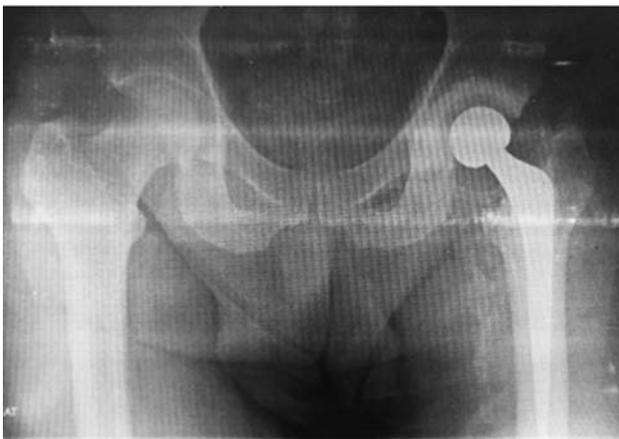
Panoramic anteroposterior radiograph of the pelvis 10 months after surgery. Note the well-positioned cemented total prosthesis at the left hip.
